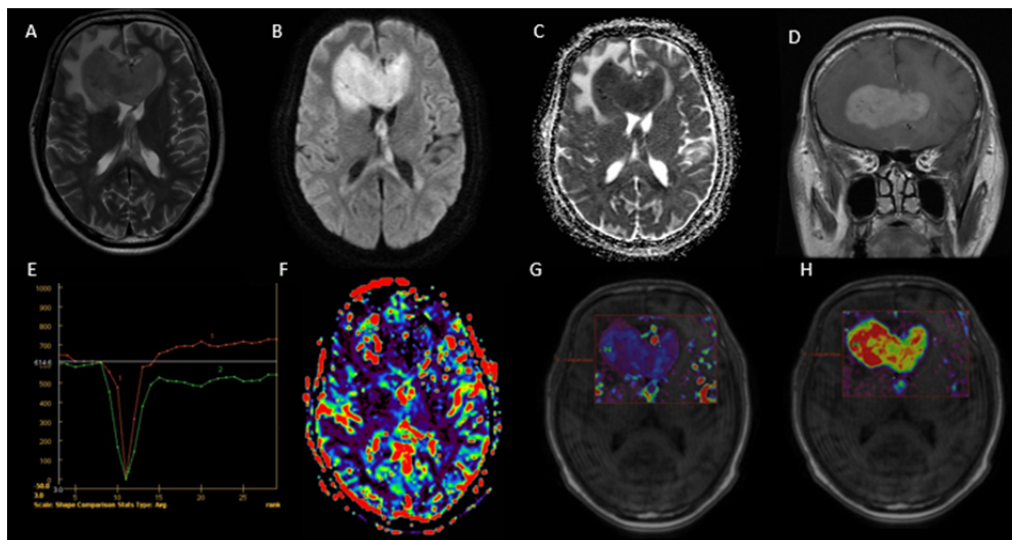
T2WI (A) images demonstrate a T2 iso to hypointense solid intra-axial lesion epicentred in the genu of corpus callosum. Almost whole of the lesion appear markedly hyperintense on DWI (B) and hypointense on ADC (C) , consistent with diffusion restriction. The lesion shows homogeneous postcontrast enhancement with no evidence of cystic/necrotic appearing areas (D). The mean curve of DSC perfusion shows rapid signal overshoot above the baseline (E). Mild increase in rCBV values is noted on DSC perfusion. Significantly increased values of, k-trans (G) and Ve (H) are observed on DCE MR perfusion.
